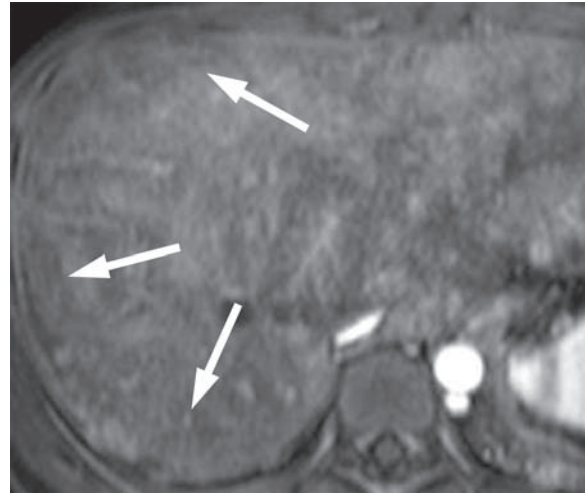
Chronic IVC obstruction in a 21-year-old woman with Budd-Chiari syndrome. Gadolinium-enhanced three-dimensional gradient-echo T1-weighted volumetric interpolated breath-hold examination (VIBE) MR image (3.8/1.7, 12° flip angle) shows heterogeneous enhancement with a reticular pattern (arrows), especially at the periphery of the liver.
